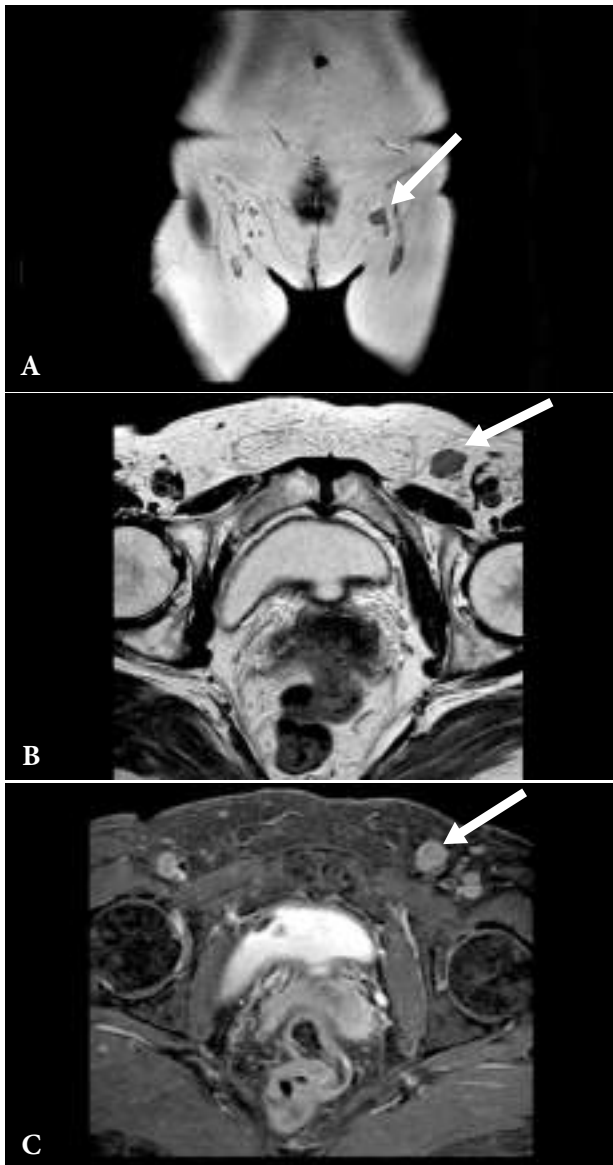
Pelvic MRI showing a suspicious, pathologically altered left inguinal lymph node (marked with arrow) in: A) T2W coronal plane, B) T2W axial plane and C) T2 SPAIR axial plane.
